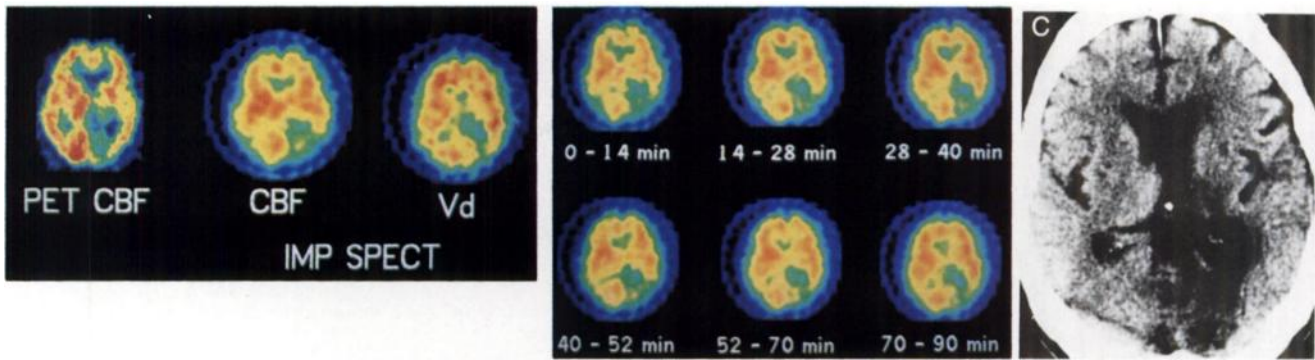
(A) Comparison of a ^{15}O -water PET CBF image with CBF and V_d images from a patient with chronic cerebral infarction (Subject 4). The two CBF images are similar, and low V_d values are observed in the infarcted region in the left posterior cerebral artery territory. A discrepancy between the CBF and V_d result is observed around the region, i.e., the size of the defect is smaller in the V_d case. (B) Images obtained by adding frames of IMP dynamic SPECT for a patient with chronic cerebral infarction. The early image (0–14 min) agrees well with the CBF image technique, and a delay in scanning is associated with a distribution closer to the V_d image (Fig. 2A). (C) An x-ray CT image from the same patient. A low density area, i.e., the infarcted region, is observed in the left posterior cerebral artery territory.
